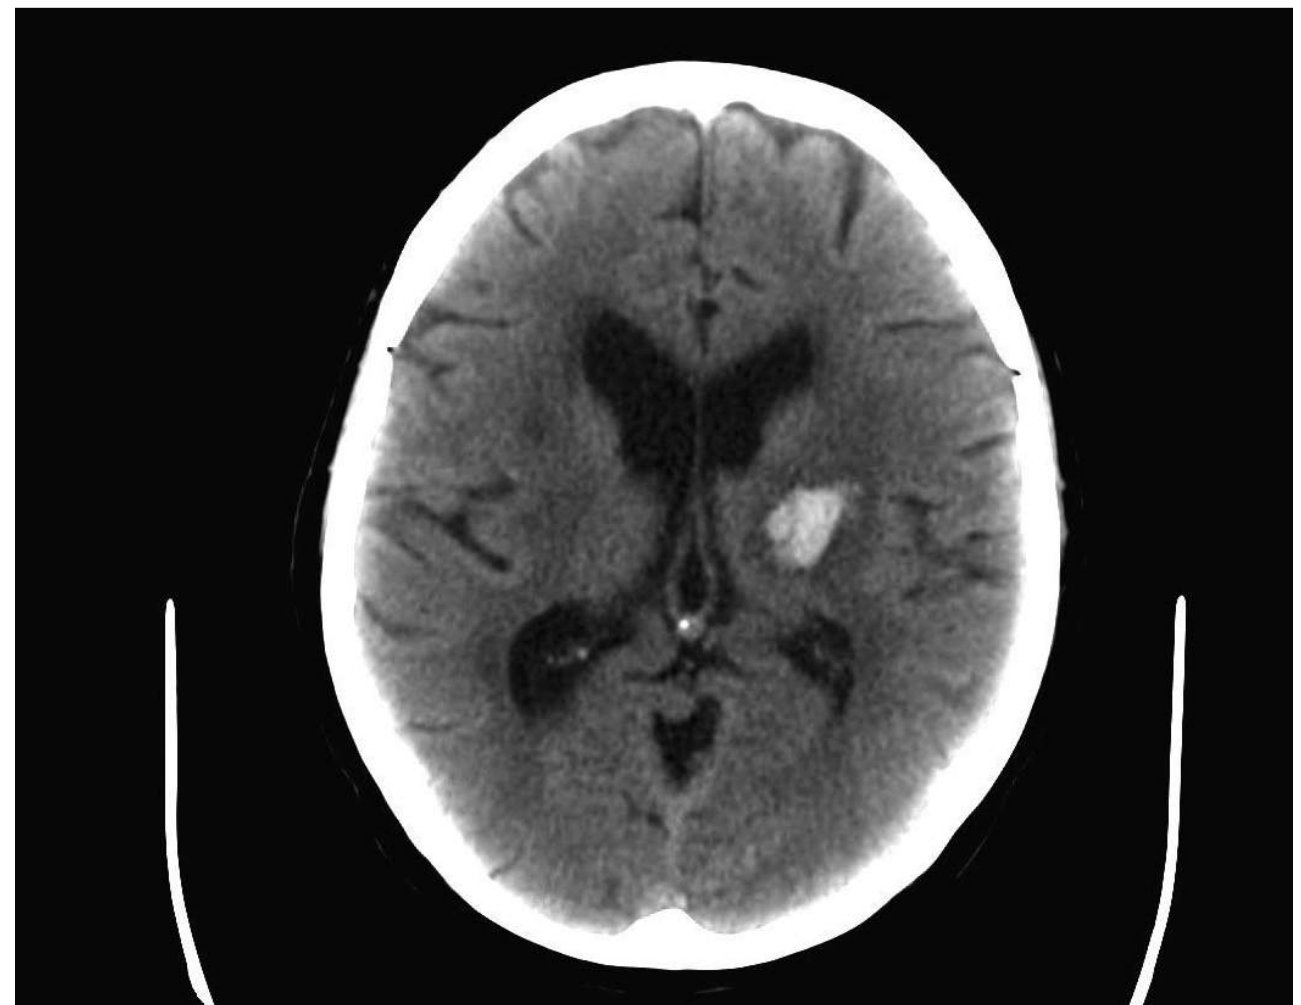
CT hypertensive hemorrhage. Note the left thalamic hemorrhage; this most commonly results from damage to the penetrating branches of the posterior cerebral artery. The site of hypertensive hemorrhages is most commonly in the territory of perforating vessels (basal ganglia—lenticular striate arteries; pons—basilar perforators; thalamus—thalamoperforators).
